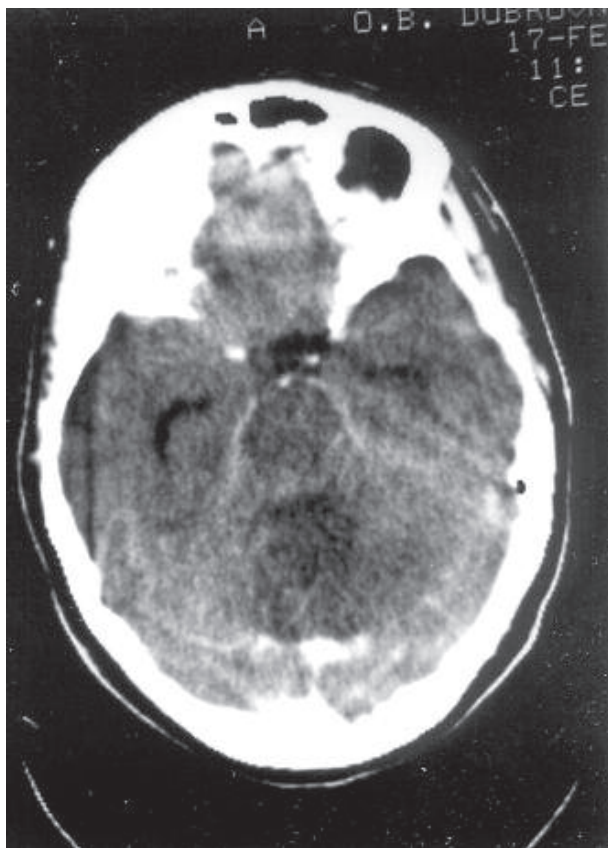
Computed tomography scan showing hypodensity in the region of vermis and left cerebellar hemisphere.
